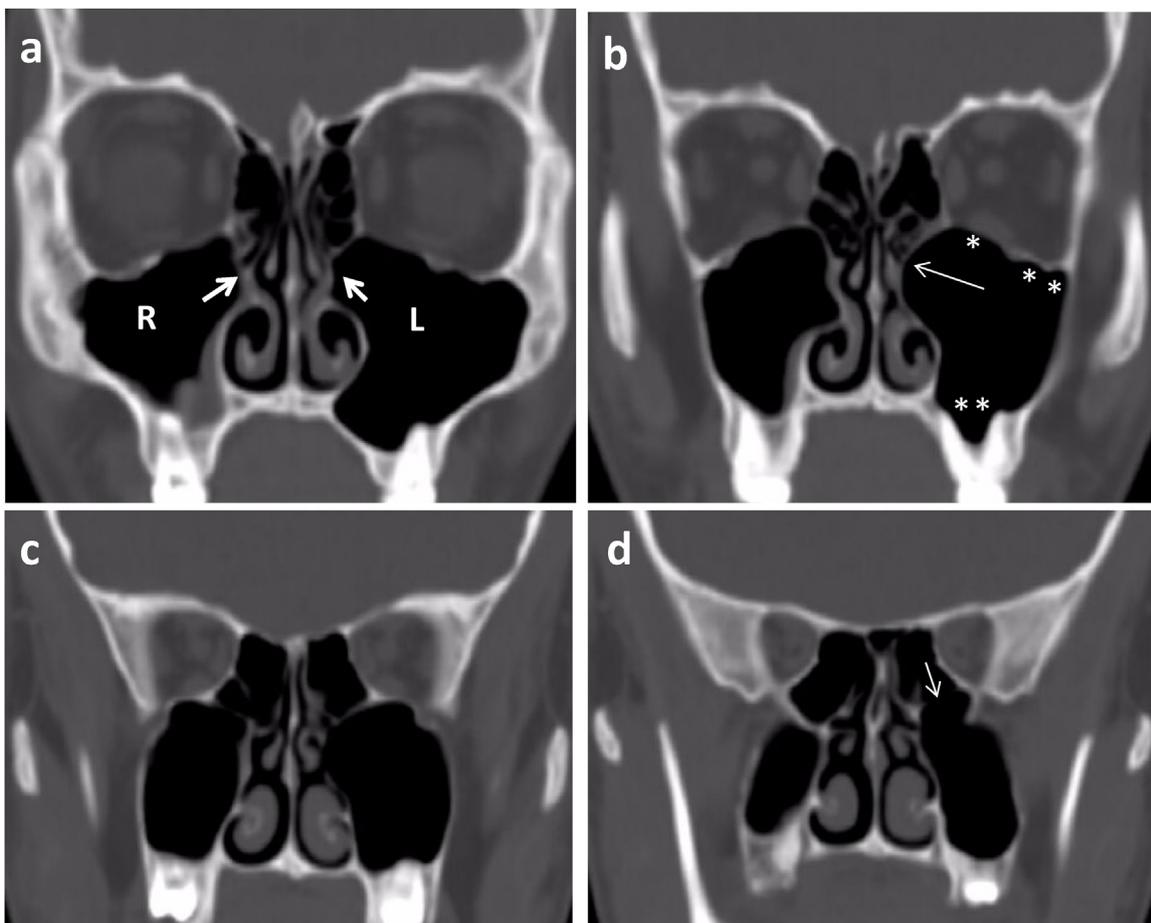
CT scan of the nose and paranasal sinuses, coronal sections: a: section through the nasomaxillary canal (arrow), which is large on the right side (R) and narrow on the left side (L); the left maxillary sinus appears to be larger than the right maxillary sinus; b: the soft tissue wall of the fontanelle region, which forms the nasomaxillary septum posteriorly to the ostial region, protrudes medially (arrow), obstructing the left middle meatus; the left maxillary sinus appears to be larger than the right maxillary sinus and its polyhedral pneumatization leaves expansive impressions on the inferior wall of the left orbit (*) and in the alveolar recess (); c: a posterior coronal section confirms the previous findings and the absence of mucosal hypertrophy or retention; d: pneumatization of the left maxillary sinus extends towards the posterior ethmoid, from which it remains separated by only the maxillary membrane (arrow).
